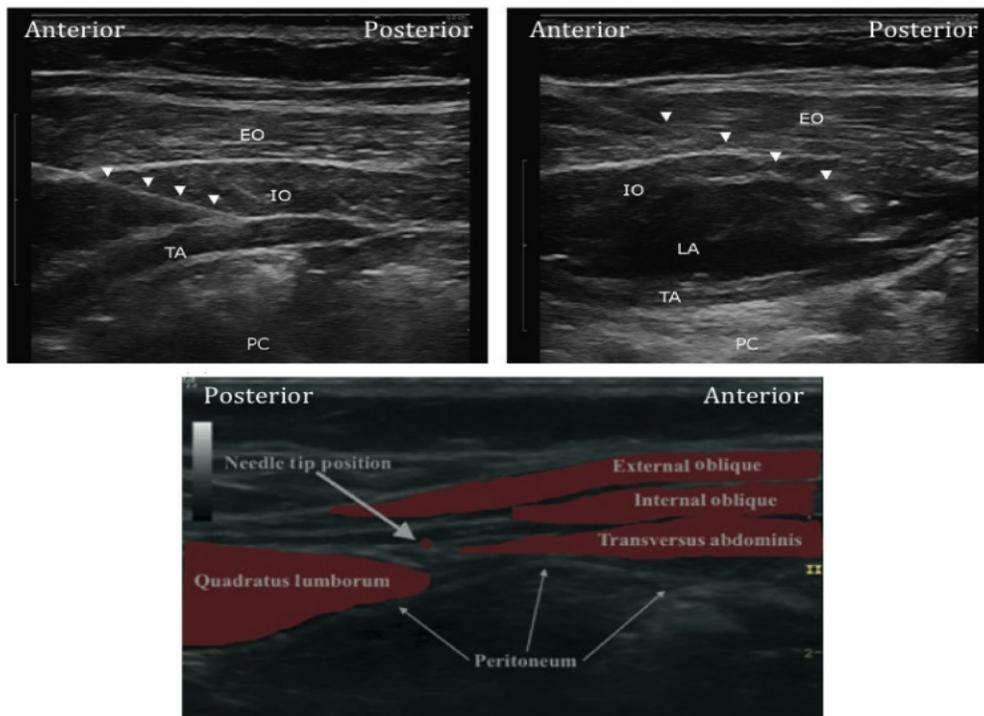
Ultrasound Guided Posterior Tap Block
